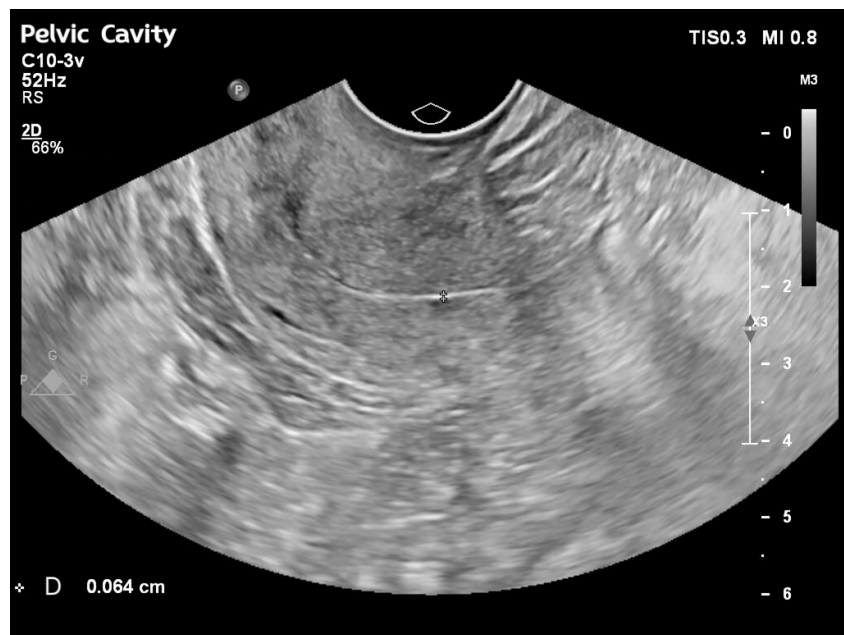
Preoperative ultrasonography showing the echo of the Intrauterine Device (IUD) within the uterus. The position marked by the arrow in the figure is the IUD.
